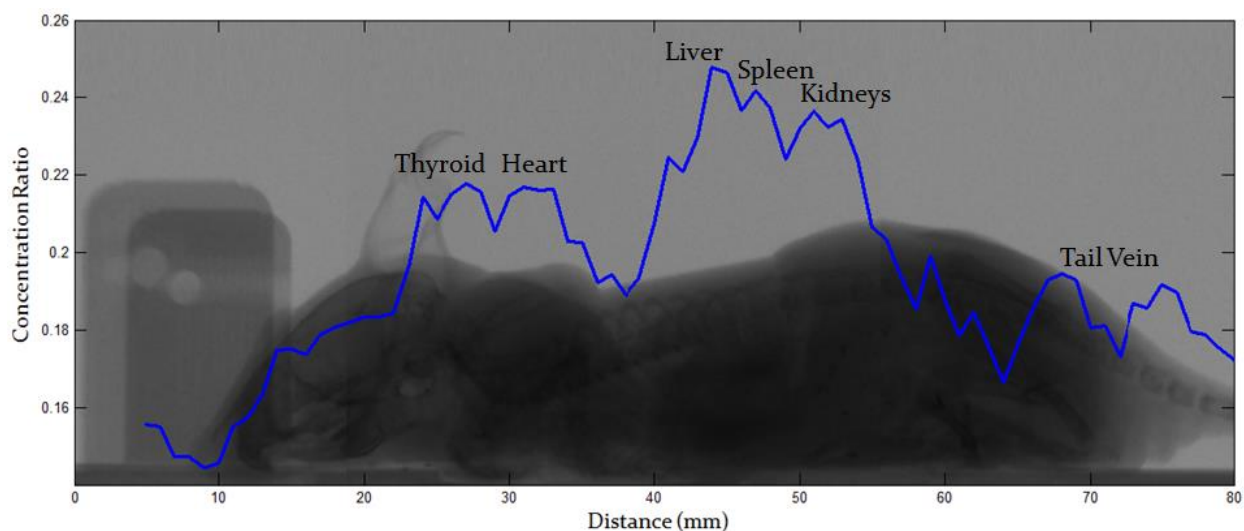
Fluorescent signal vs position graph overlaid on a sagittal projection X-ray. 1 minute perfusion; 1 mm/step, 20 s/step, 80mm total scan distance
